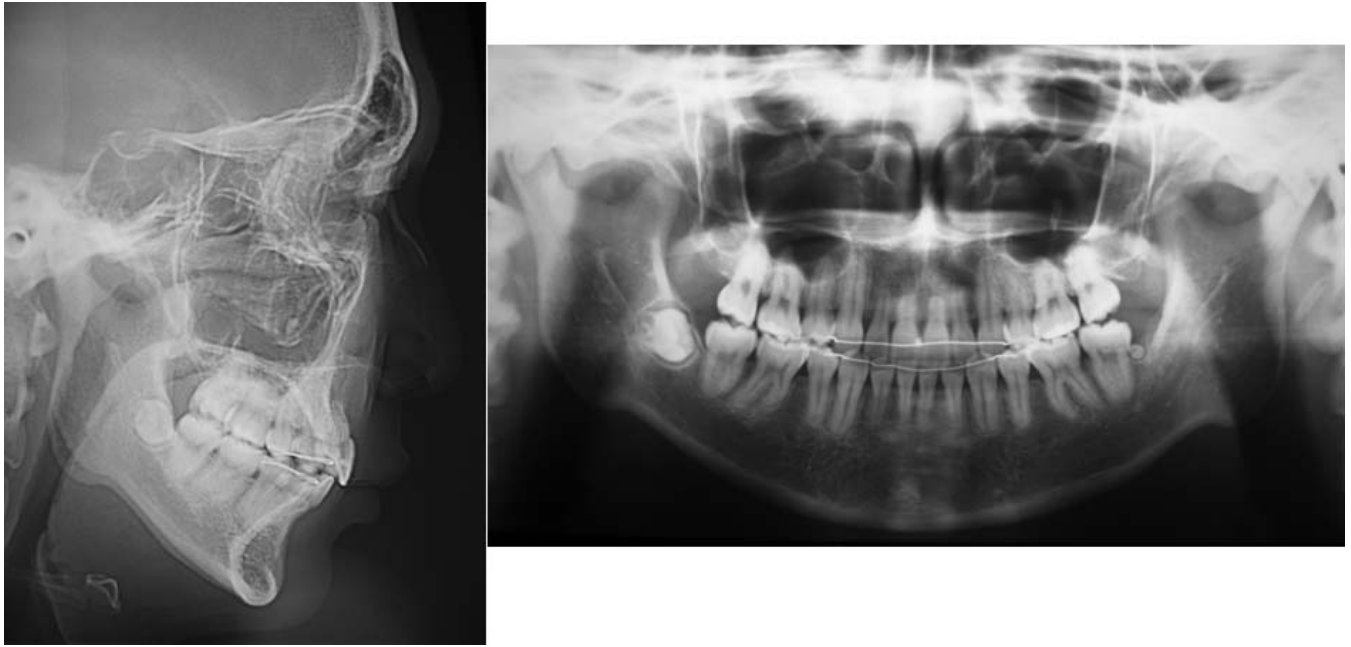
Cephalometric and panoramic radiographs after treatment (age 17 years 8 months).
